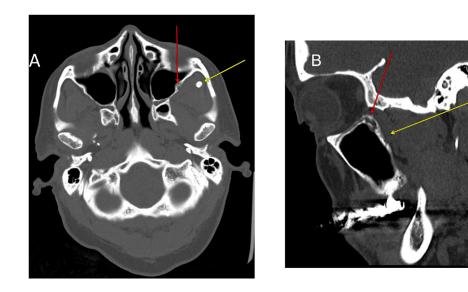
Axial CT images at the level of the adenoid tonsils (A) and sagittal CT images at the level of the left maxillary sinus (B) demonstrate bony remodeling of the posterior wall of the left maxillary sinus (red arrows) and isodense lesion within the buccal space, with obliteration of the normal fat planes (yellow arrows). Note round calcification, likely phlebolith within the lesion on axial images.
